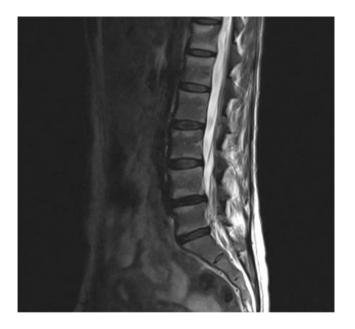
Spinal magnetic resonance image: hyperintense signal changes in T2-weighted sequences extending from the endplates to the corpora throughout the spine.
